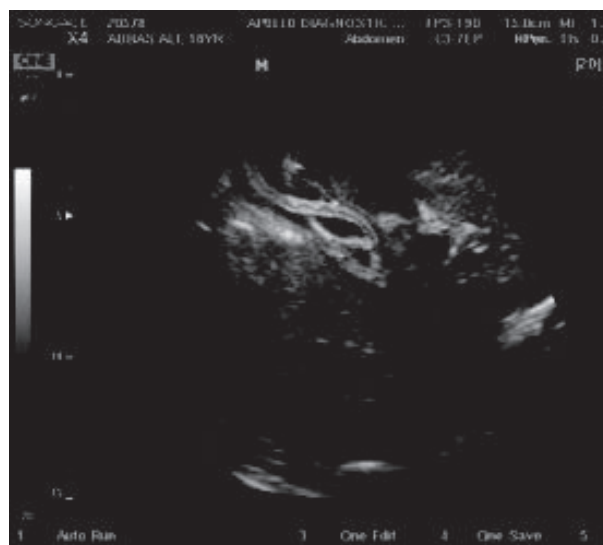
Tubular overlapping echogenic structure within the biliary tree (Spaghetti sign) at ultrasonography
